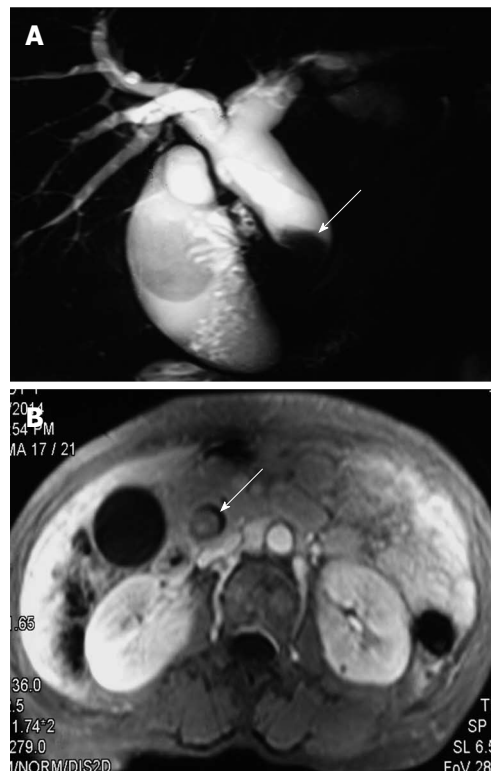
Imaging presentation of biliary tract intraductal papillary mucinous neoplasm. A: Magnetic resonance cholangiography shows dilation of proximal biliary tract and a filling defect in the extrahepatic bile tract (arrow); B: Magnetic resonance imaging shows an intraluminal polypoid lesion originating from the extrahepatic bile tract (arrow).
